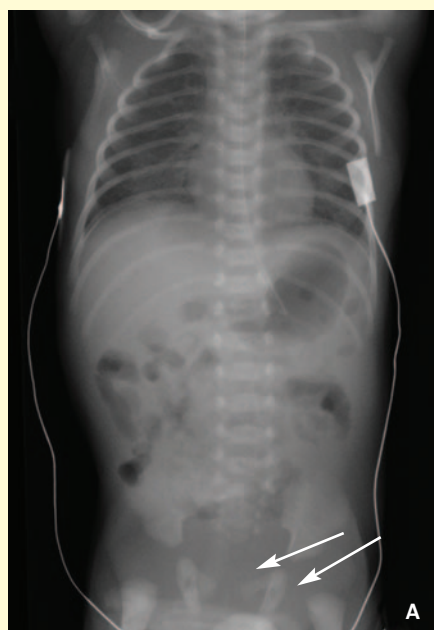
A one-day-old baby born at 36 weeks' gestation with bilious vomiting and very poor feeding. (A) A plain radiograph pre-malrotation showing a non-specific bowel gas pattern with gas seen within the distal bowel (arrows). (B) A plain radiograph post-malrotation: the double bubble sign is seen with no gas distally. (C) An upper GI contrast study: contrast is confirmed in the small bowel in the right side of the abdomen with no evidence of crossing the midline to the left. The appearance is in keeping with malrotation.
